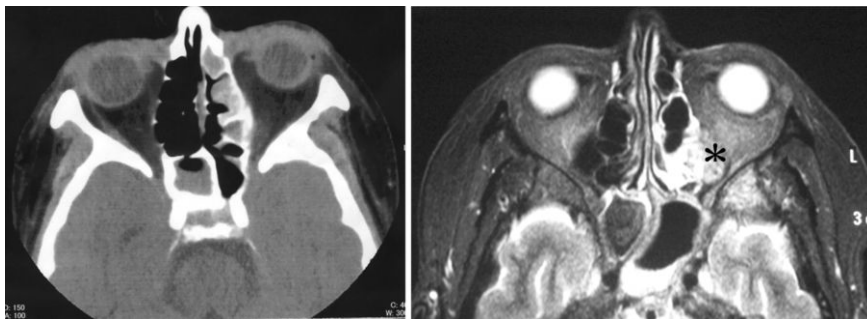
Preoperative magnetic resonance imaging and computed tomography . The disturbed area of the left orbital apex (asterisk) showed high intensity by T2 weight (right), but could not be identified by computed tomography (left).
